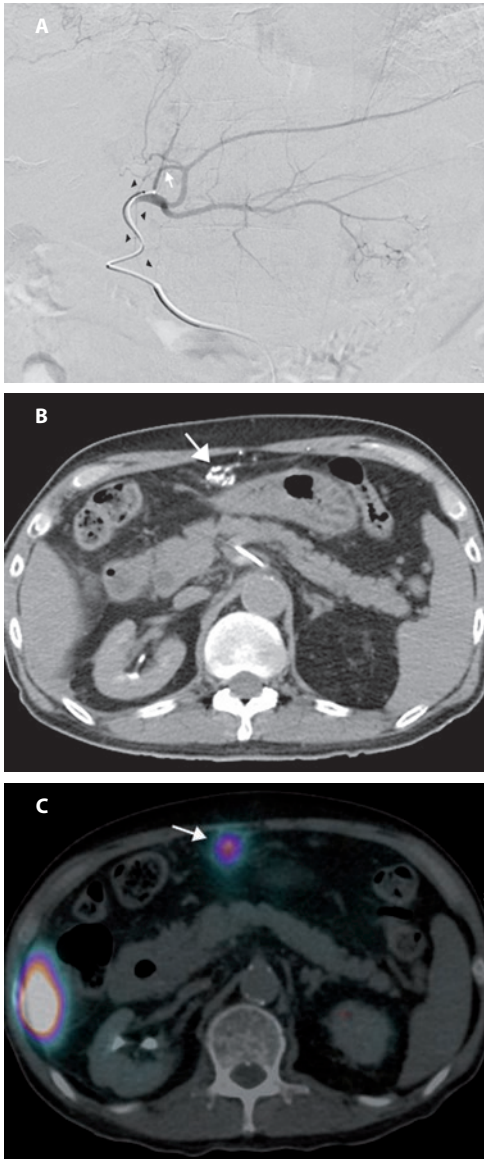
Patency and coil embolization of the HFA in a 74-year old male with multifocal bilobar HCC. a) Selective DSA from the left hepatic artery shows a small HFA (arrowheads) originating from a segment 4 artery (white arrow); b) CTHA performed with the same catheter position shows opacification of an anastomotic network of arteries (arrow) via the HFA. Branches of this network lead to the anterior abdominal wall (not shown); c) After injection of ^{99m}Tc -MAA into the left and right hepatic artery, SPECT/CT detected ^{99m}Tc -MAA activity in the trajectory of the HFA and the anastomotic network (arrow). At the time of actual treatment, the HFA was selectively catheterized and embolized with micro-coils prior to infusion of Y90 microspheres into the left and right hepatic artery.
